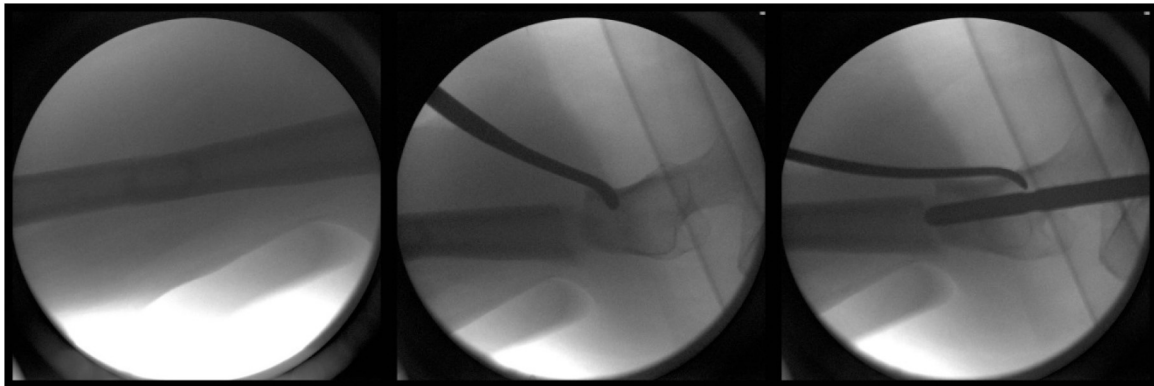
Intraoperative radiographs revealing (A) provisional reduction of the diaphyseal fracture with pord device, (B & C) reduction of flexion deformity allowing accurate nail starting point.
